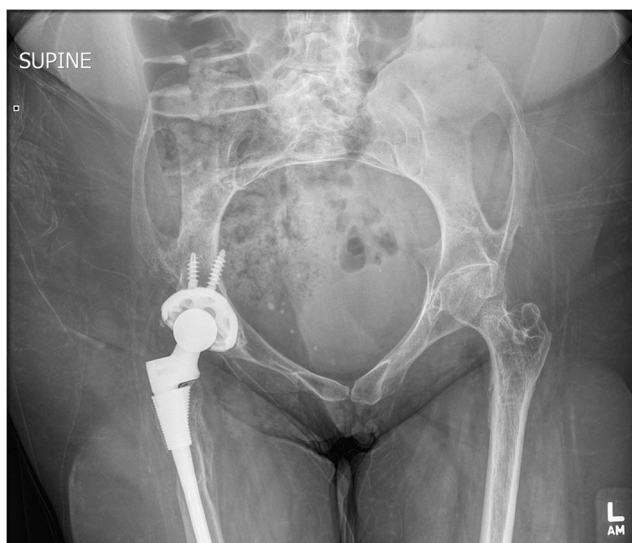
AP radiograph of the pelvis
